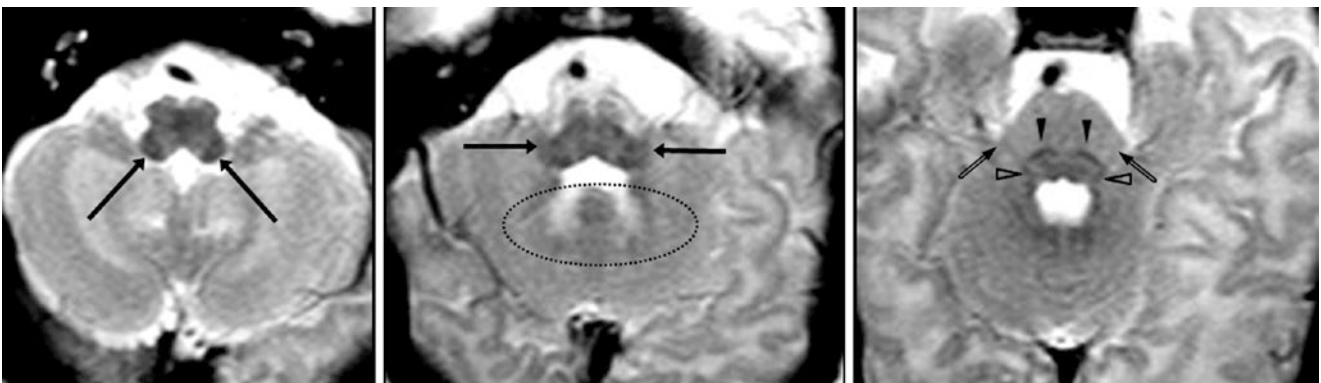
A 21-day-old term neonate had a normal 3T MRI with SE T2WIs, which demonstrate the ICP (*long arrows*) at two levels. Also, note the LL (*open arrowheads*), ML (*arrowheads*), and cranial nerve V
